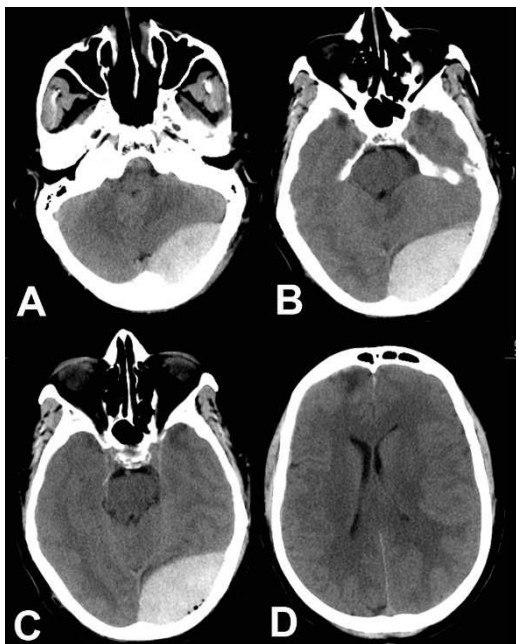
Pre-operative CT scan brain plain showing a large posterior fossa extradural hematoma with mass effect and small speck of right frontal contusion (please note the small size and distortion of the fourth ventricle)
